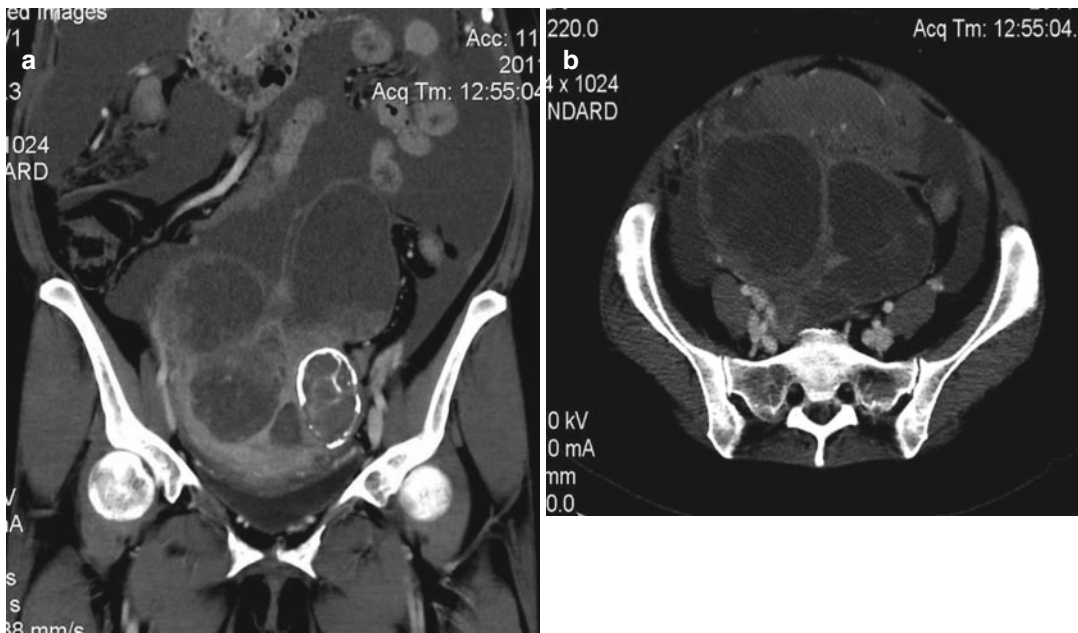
(a, b) Contrast-enhanced axial and coronal CT showing uterine enlargement with lobulated contour with enhancing solid areas and low-density necrotic masses;
